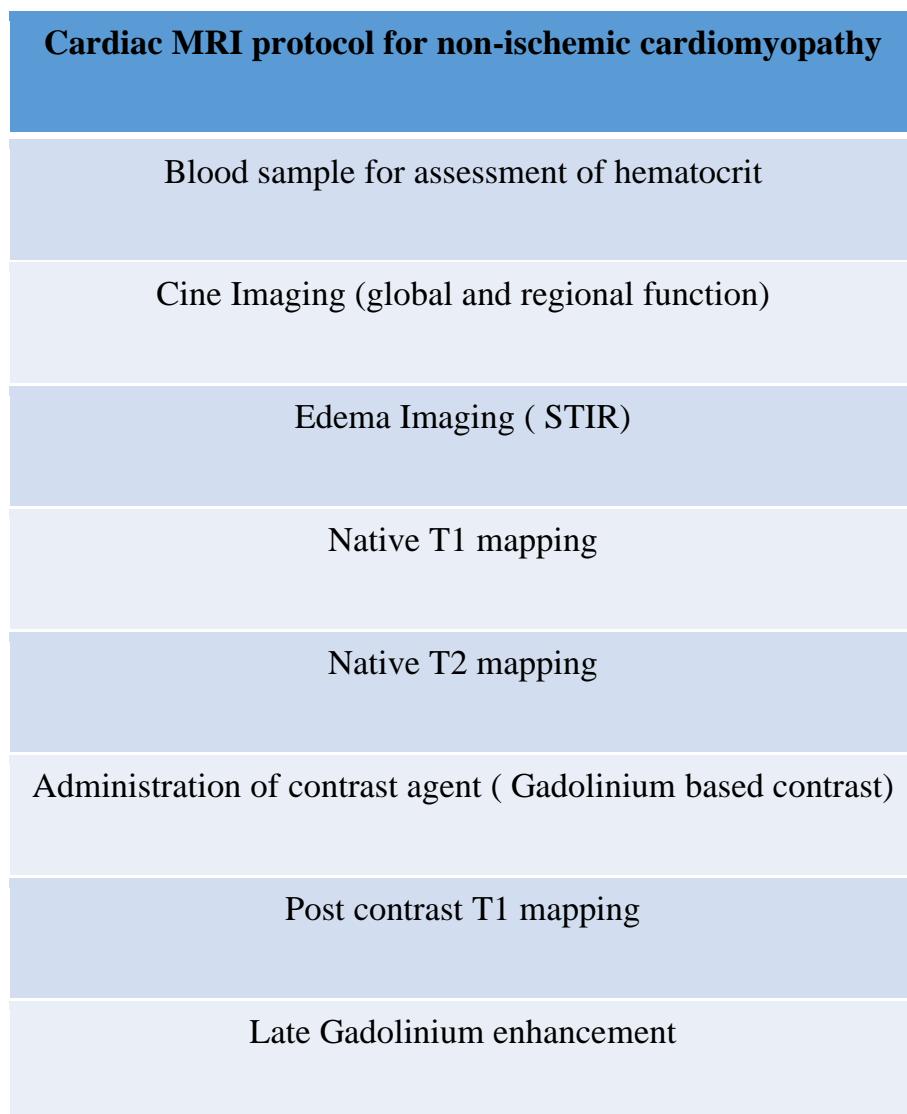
Cardiac MRI protocol for non-ischemic cardiomyopathy
